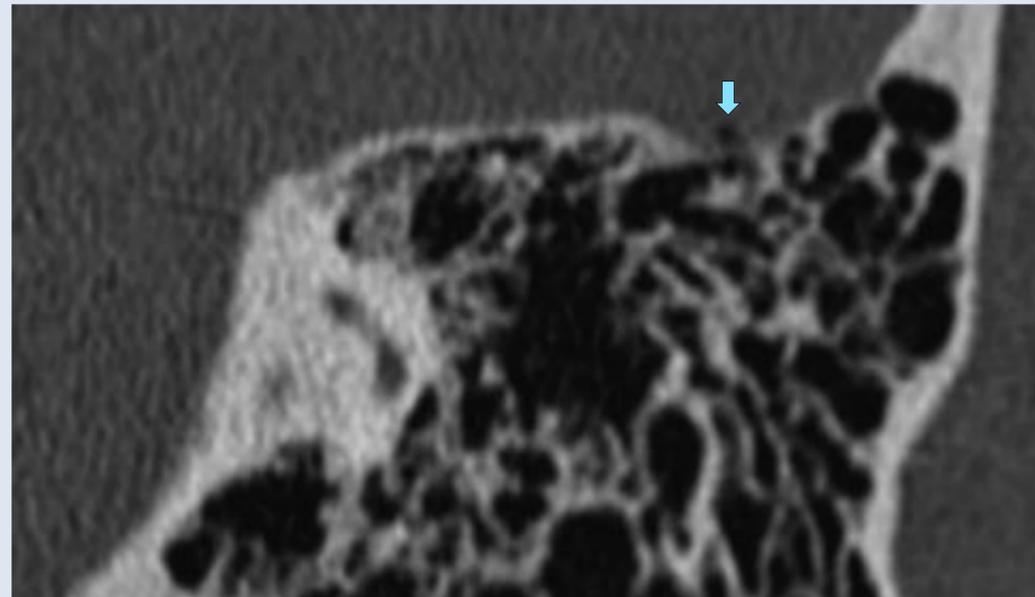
High resolution skull base CT showing an intraparenchymal air bubble, associated with a small underlying bony defect in the posterior part of the left petrous bone (blue arrow).
